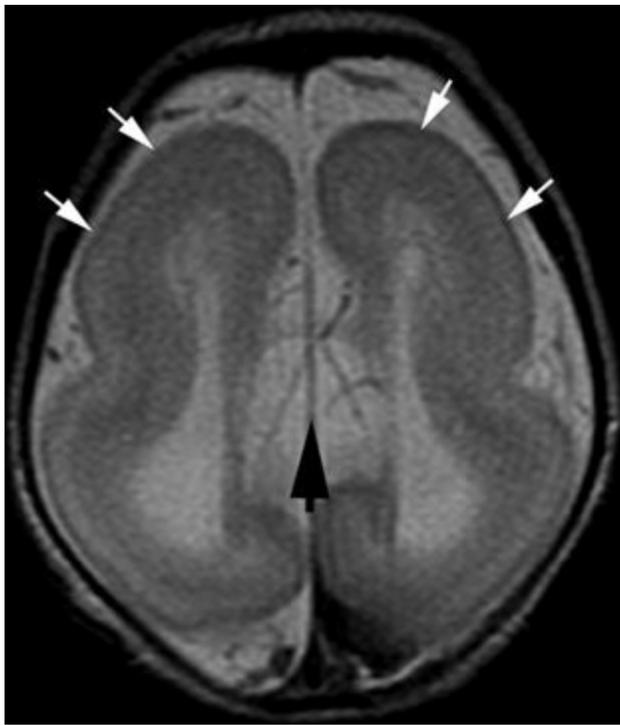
Lissencephaly. Axial T2-weighted image from MRI without gadolinium in a newborn shows lack of normal sulcation (white arrows), parallel lateral ventricles, and absence of the corpus callosum (black arrow). Children with lissencephaly usually present with epileptic spasms, severe global developmental delay, microcephaly, and marked hypotonia during early infancy.
